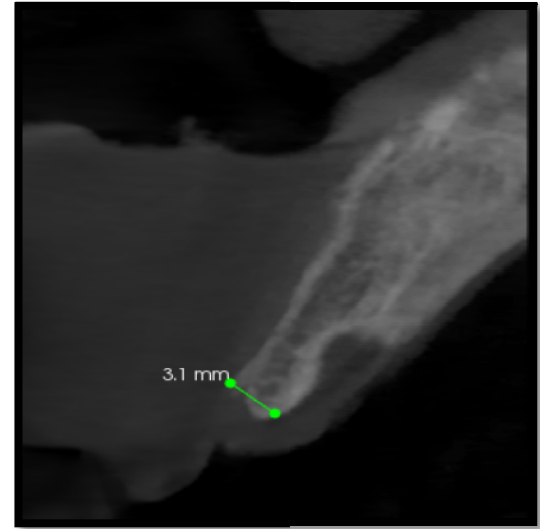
CBCT section showing deficient bone width buccolingually (3mm)
